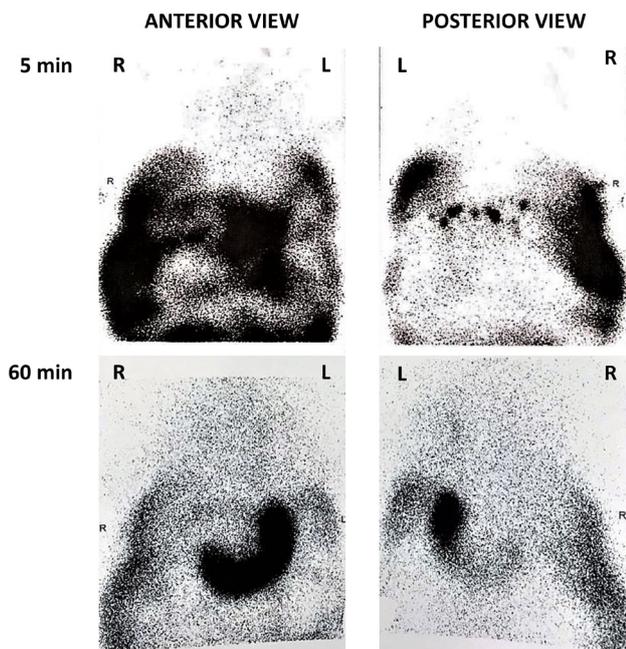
Peritoneal scintigraphy demonstrated extravasation of dialysate containing radioactive ^{99m}Tc -pertechnetate into bilateral pleural cavities.
